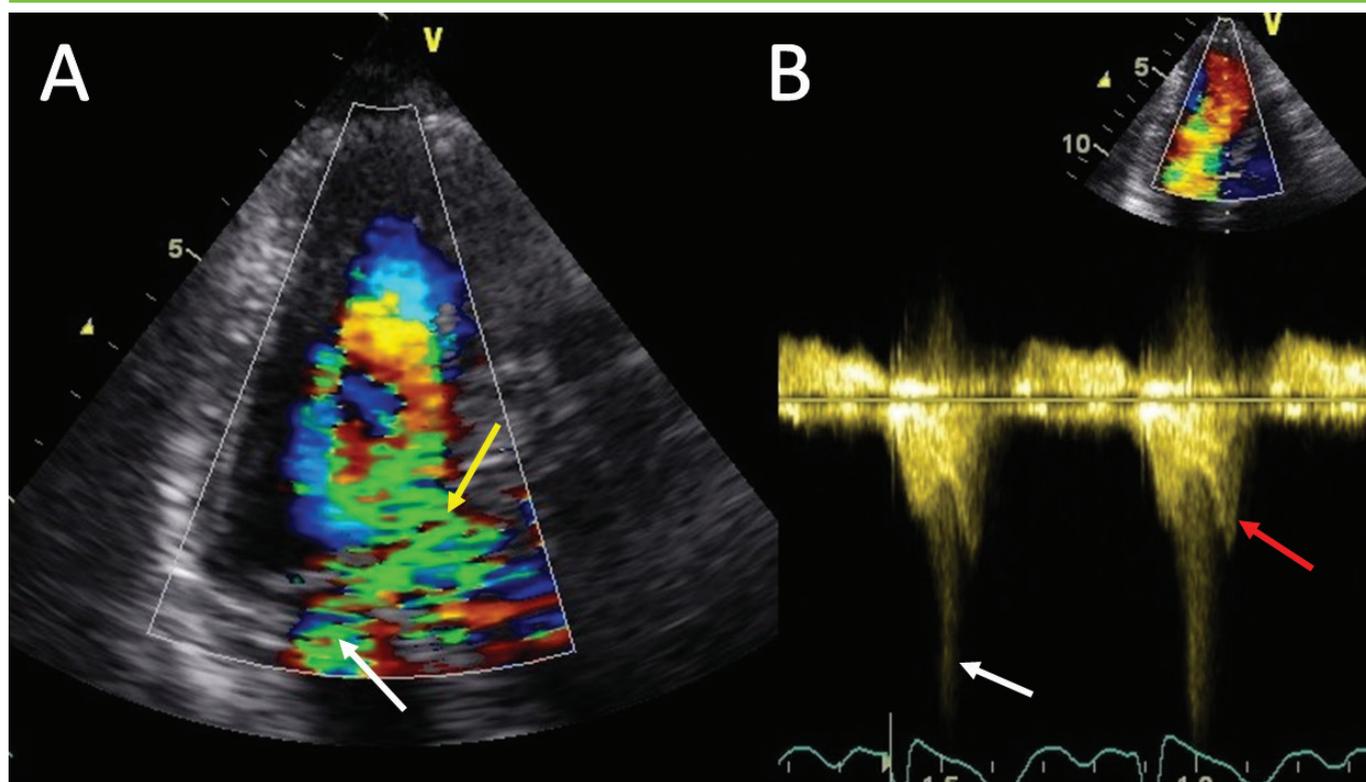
Echocardiogram (A) during the acute phase of Takotsubo cardiomyopathy showed left ventricular outflow tract obstruction (yellow arrow) with dynamic mitral regurgitation (white arrow). On colour Doppler (B), there was late systolic Dagger shape appearance consistent with dynamic obstruction (red arrow). The white arrow showed the signal of mitral regurgitation.
